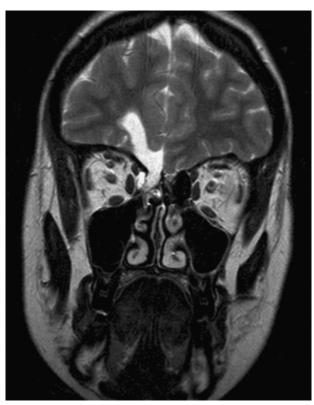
MRI of a patient with a past medical history of "uneventful sinus surgery" 7 years ago. Patient suffers from intercurrent meningitis. Image shows residual findings of a skull base laceration (loco typico) with residual signs of trauma of the neighbouring brain tissue.
